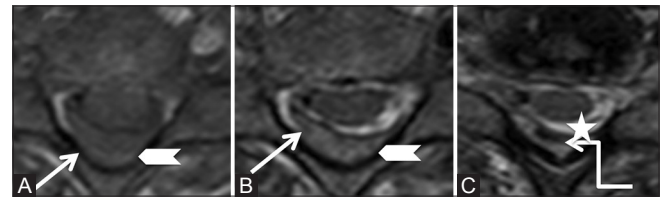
(A-C): Miscellaneous: Post-traumatic epidural hematoma: Axial T1-weighted (A), T2-weighted (B,C) images showing posterior epidural soft tissue (arrowhead) appearing hypointense on T1-weighted, hyperintense on T2-weighted, and showing hemosiderin foci within (star). It indents on the right hemicord
